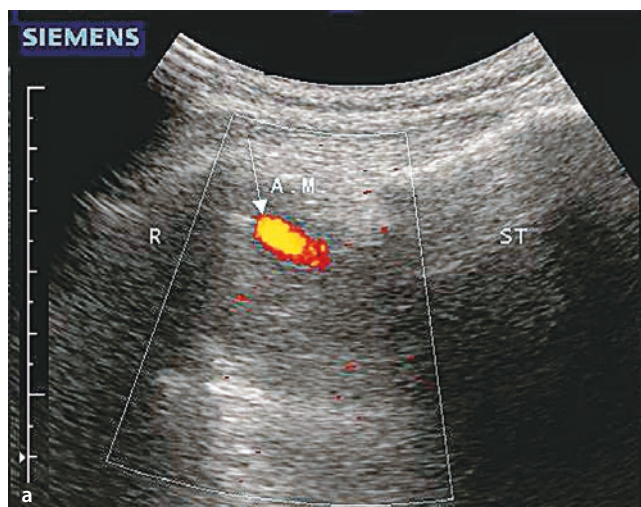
a Mediastinal tumor. Parasternal plumb line in the right lateral position. Hypochoic, indistinctly delineated mass (located in the color window). Color-Doppler sonography in “power” mode shows
